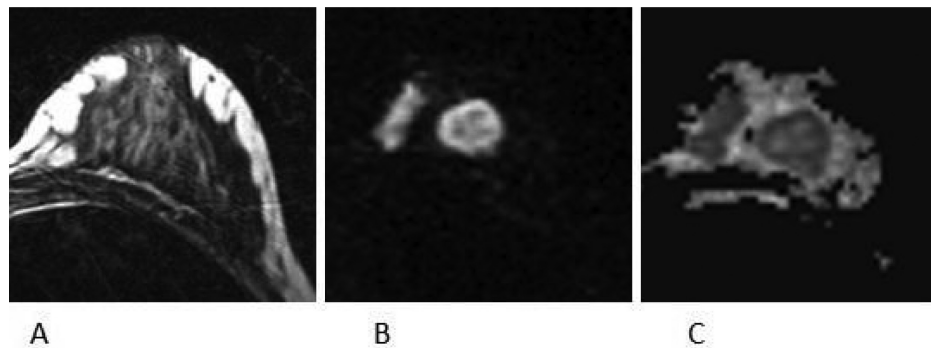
Invasive ductal carcinoma of 21 mm. Due to dense breast pattern tumor is not visible on the T2-weighted image (A). The mass is highly visible and has high DWI signal on the high b value image. Malignancy score was 7 (B). The ADC value was $0.56\text{--}0.72 \times 10^{-3} \text{ mm}^2/\text{s}$, measured on the ADC map (C).
